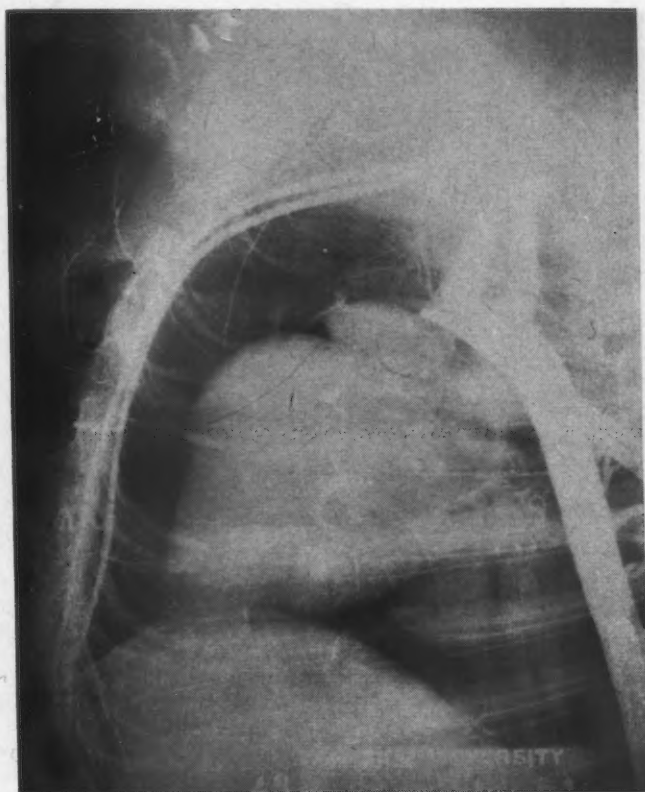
(a).—Injection of thoracic aorta via abdominal aorta with Schlesinger mass. Roentgenogram of normal heart showing no filling of the pericardium or coronary vessels.
